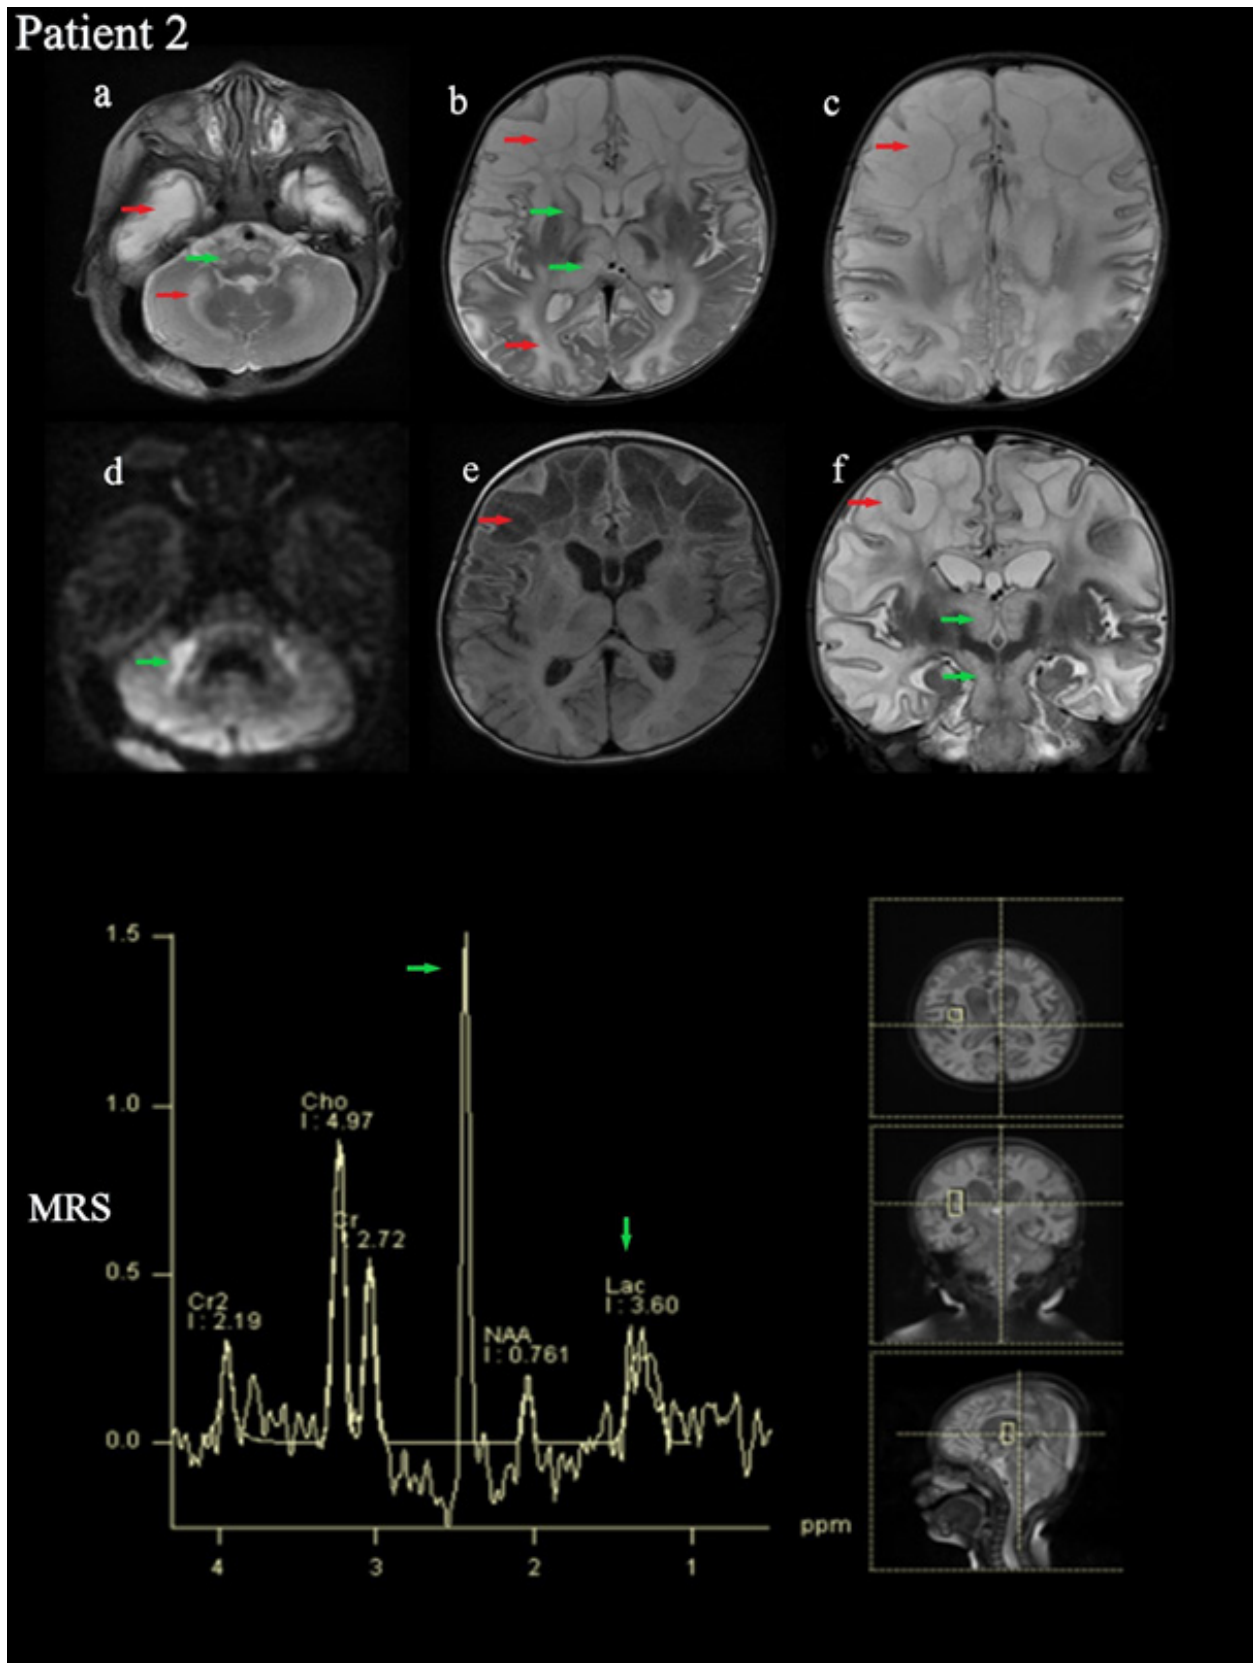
MRI images of Patient 2: Hyperintense T2 signal changes in the frontal, temporal, parietal, occipital cerebral, and cerebellar white matter (red arrows on the a, b, c, f), corpus striatum, thalamus (green arrows on the b,f), inferior olivary nucleus (green arrow on the a), corticospinal tracts at the level of the mesencephalon (green arrow on the f). Hyperintense signal changes in the middle cerebellar peduncle in the diffusion-weighted image (green arrow on the d)
